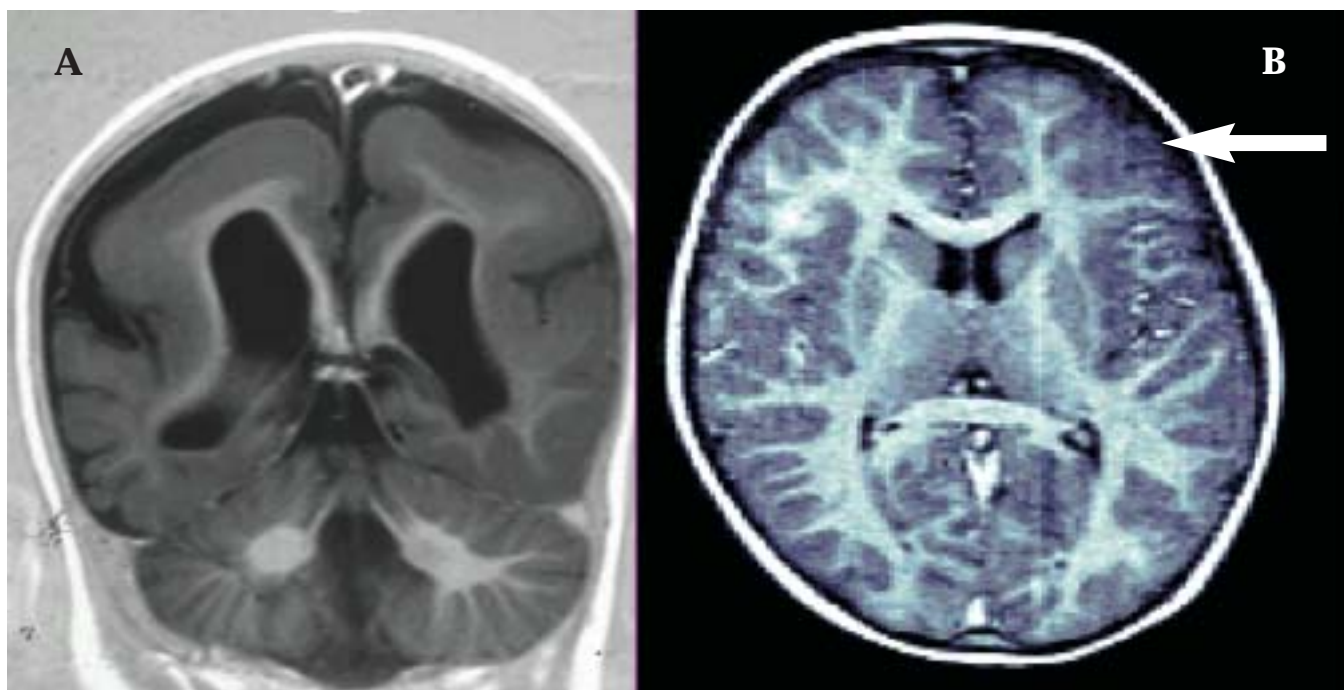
Examples of developmental brain lesions as a cause of epilepsy seen on MRI: ranging from the widespread as in lissencephaly (A, smooth cerebral hemisphere with no sulcation), to the subtle focal cortical dysplasia (B, arrowed)
